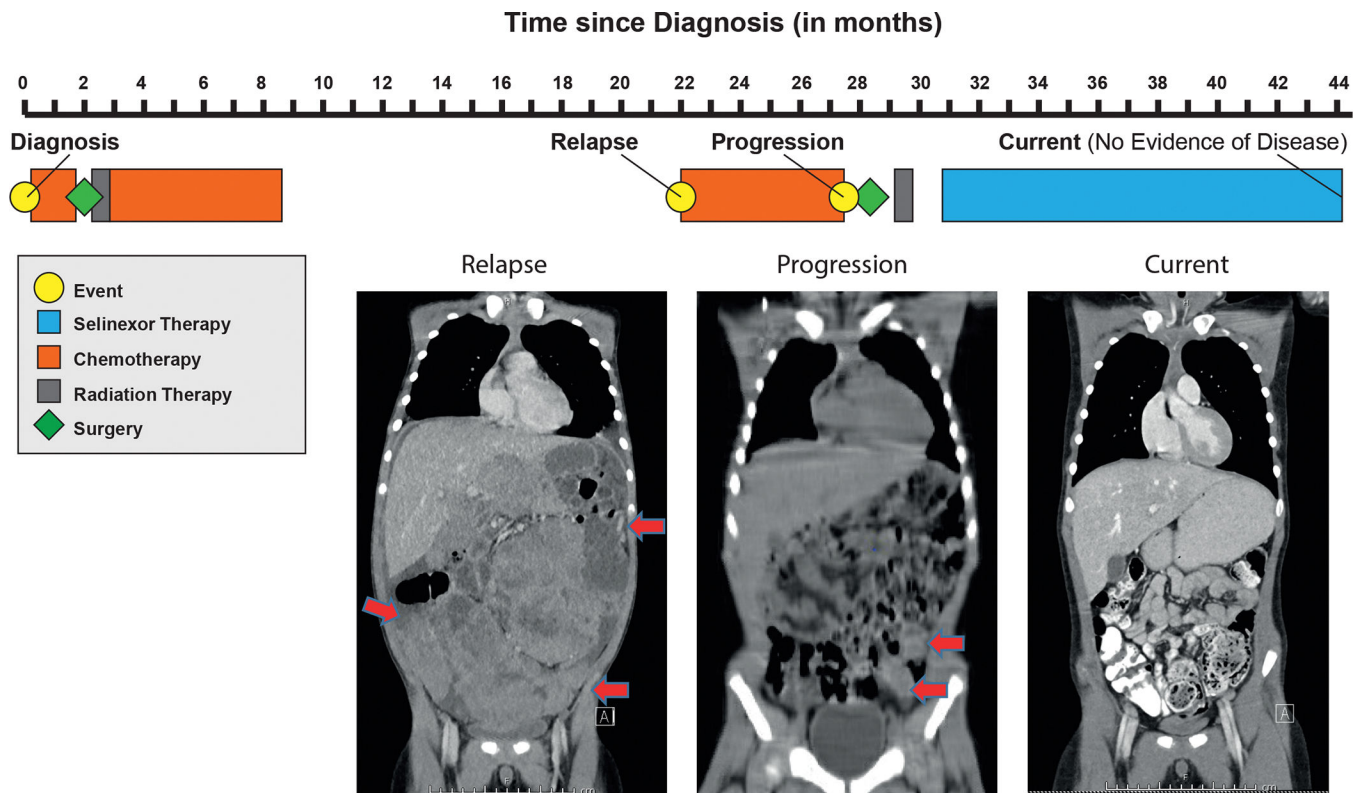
Treatment timeline of a pediatric patient with relapsed Wilms tumor treated with selinexor. Red arrows indicate peritoneal implants on MRI performed at relapse and CT performed at time of disease progression. At present, patient has no evidence of disease on selinexor monotherapy.
